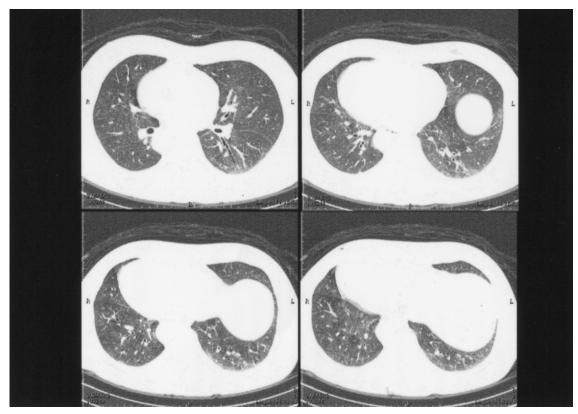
High-resolution CT of the lung demonstrates bronchial dilatation, a lack of bronchial trapering, visualization of the peripheral airways, bronchial wall thickening, and centrilobular nodules in the bilateral lower lobes.
